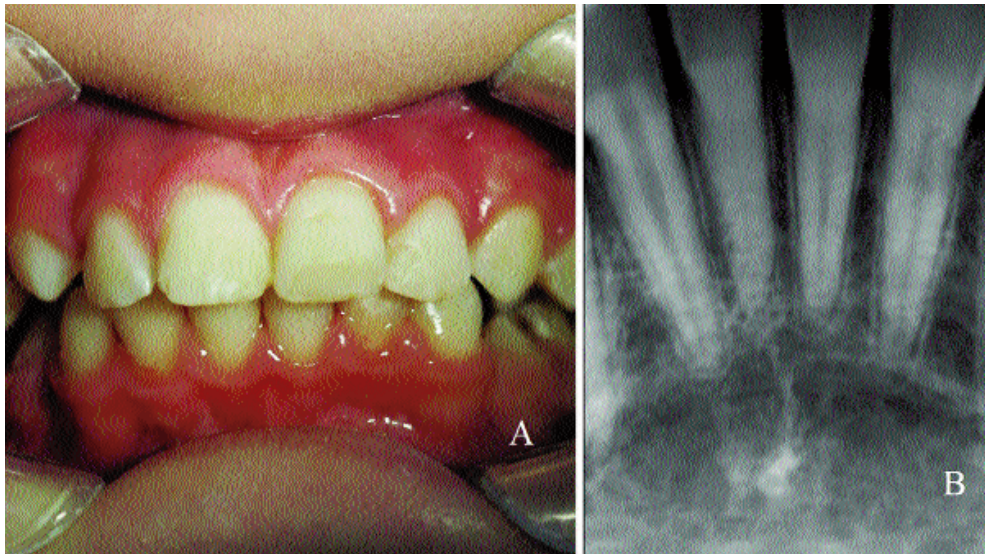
A) Intraoral view of the vital permanent incisors 24 months follow up. B) Radiograph of the vital permanent incisors with the apical closures 24 months follow up.
